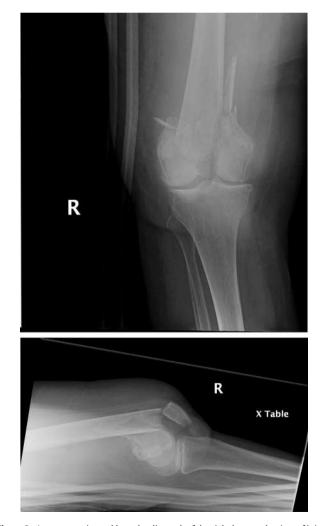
Anteroposterior and lateral radiograph of the right knee at the time of injury.
